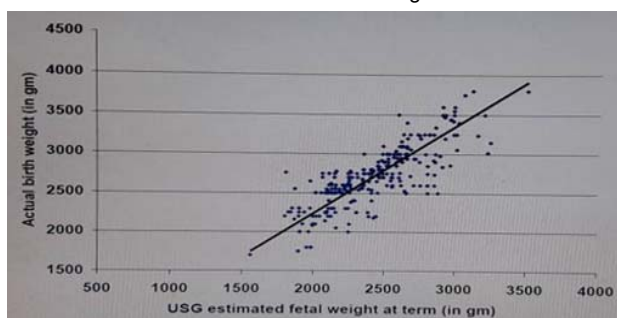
Correlation between Ultrasound Assessed Fetal Weight at term and Actual Birth Weight immediately after delivery
